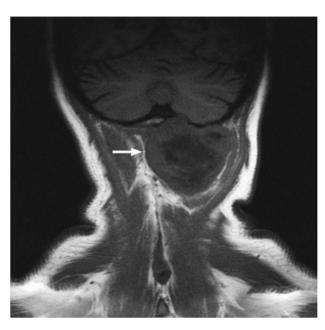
T1-weighted MRI showing the lesion eroding through the left basioccipital skull, impinging the dura overlying the left cerebellum.
